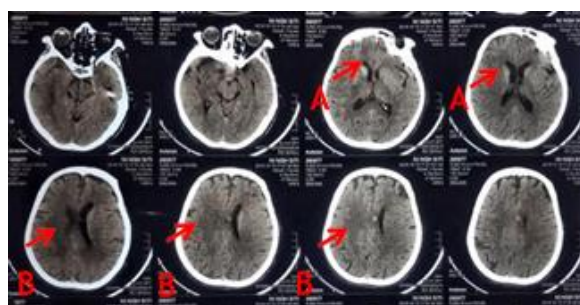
Non-contrast computed tomography scan of the patient showed (A, arrow) hyperdensity of the right basal ganglia and (B, arrow) ongoing infarction in the right temporal lobe.
